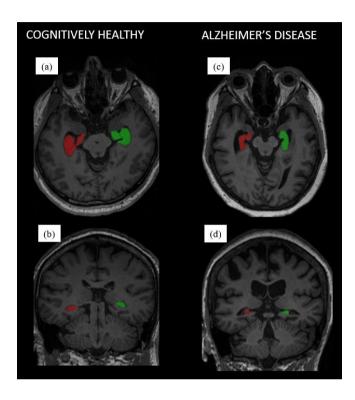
Automated MRI brain image segmentation using HippoDeep, showing the right hippocampus (red volume of interest) and left hippocampus (green volume of interest). Cognitively healthy brain segmentation in (a) axial view and (b) coronal view. Alzheimer's disease brain segmentation in (c) axial and (d) coronal views.
